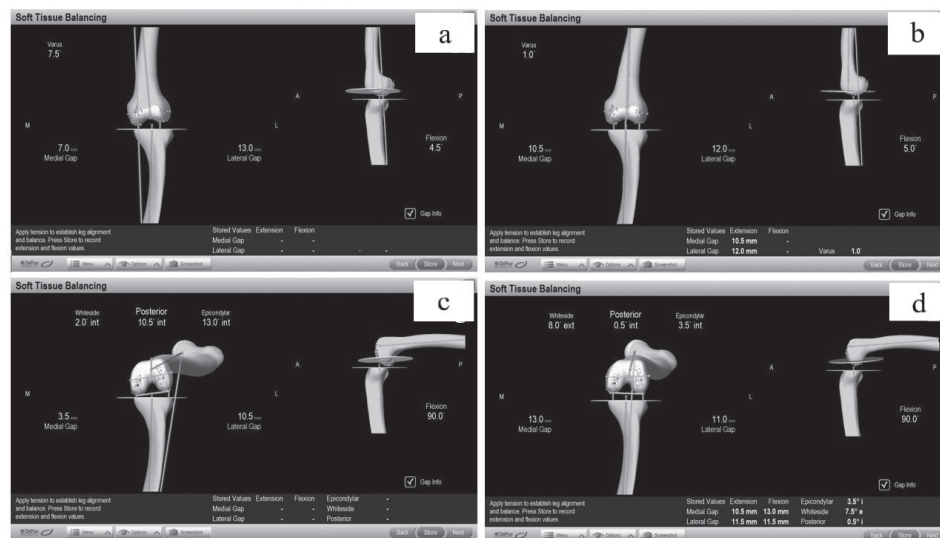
CT-free navigation software showed how to measure alignment, extension and flexion gaps
